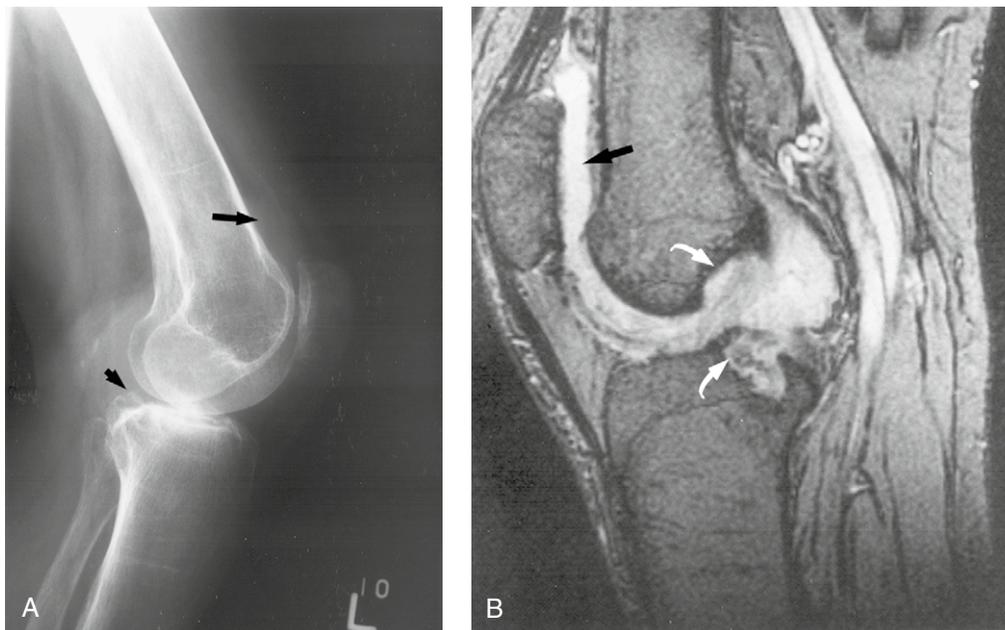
Chronic *Coccidioides* arthritis. (A) Lateral view of the left knee shows osteopenia, joint effusion (arrow) and an area of bone erosion (small arrow). (B) MR imaging of the knee (T2WI) demonstrated large areas of erosions posteriorly (curved arrow) as well as the joint effusion (arrow).
